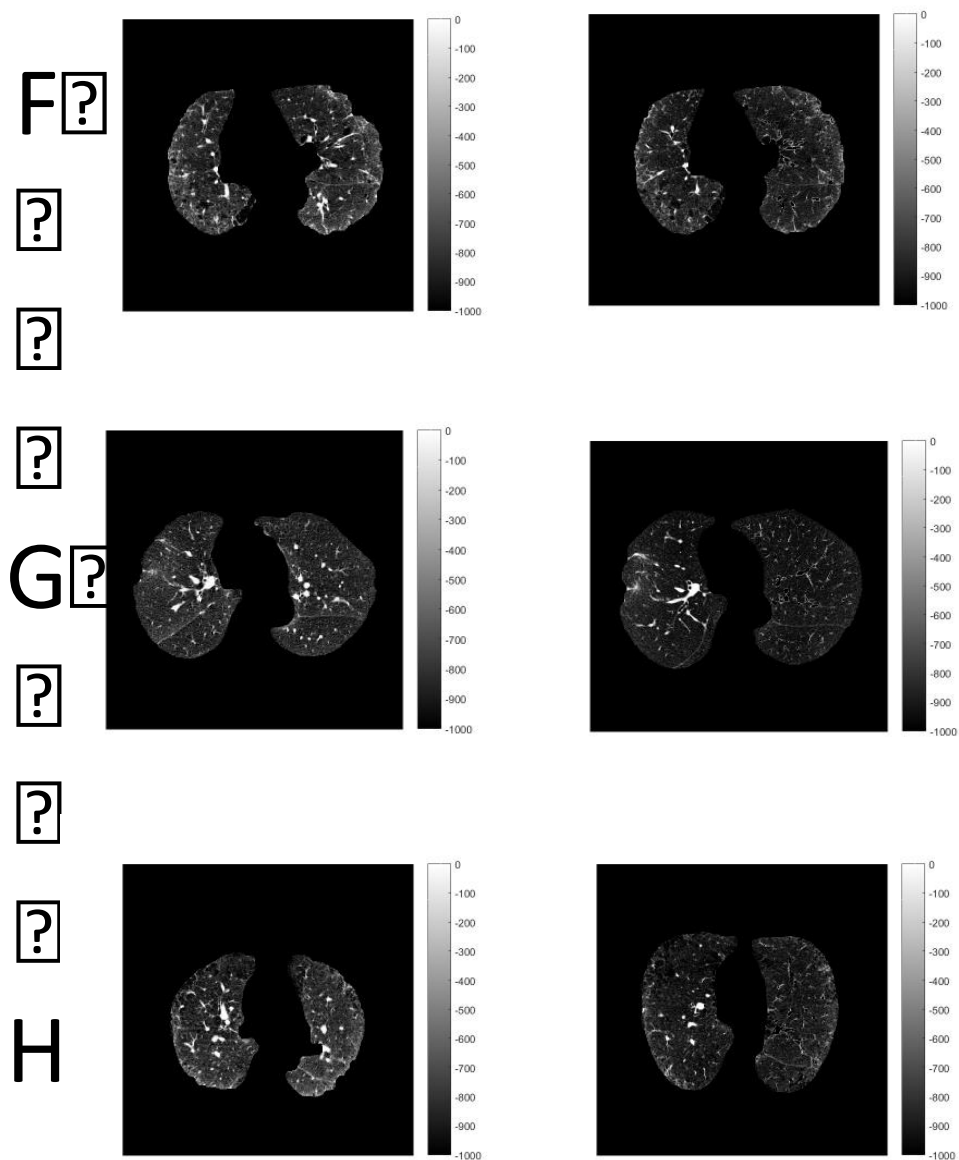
CT scans showing good segmentation (scan pairs F to Q)
